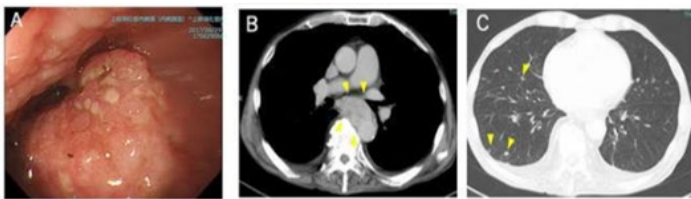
A: Upper gastrointestinal endoscopy revealed esophageal cancer in the middle thoracic esophagus. B: Computed Tomography (CT) revealed a bulky primary lesion of esophageal cancer infiltrating the left main bronchus (arrows). C: Computed Tomography (CT) revealed multiple pulmonary metastases (arrows).
